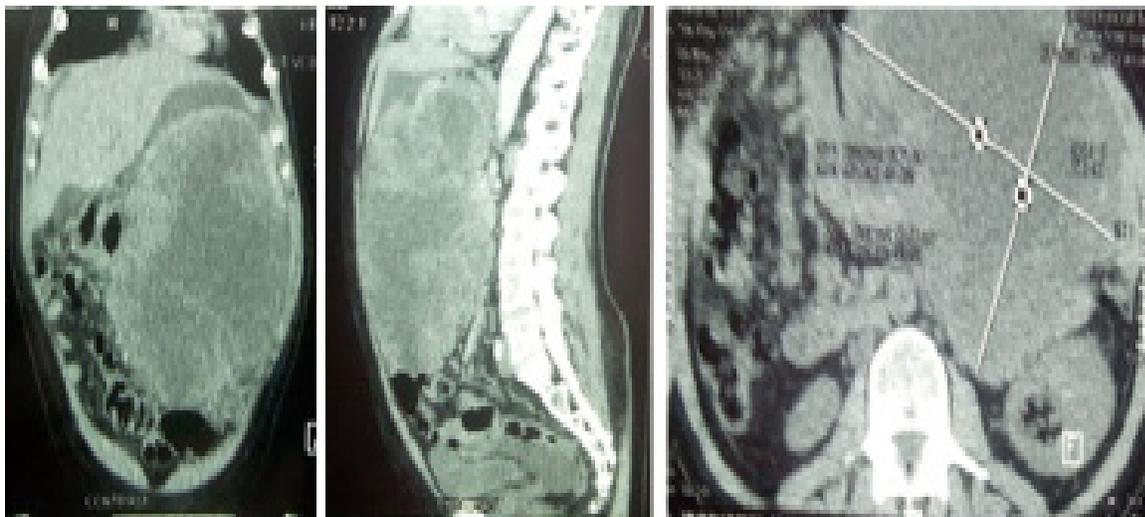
Contrast enhanced coronal, sagittal and axial CT images showing a giant tumour in the abdomen.
